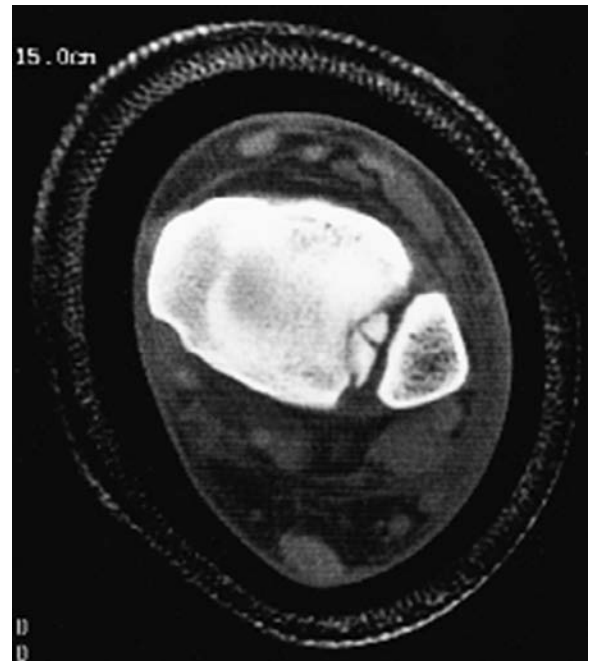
Incisural fracture: CT scan at the level of the tibiotalar joint demonstrates that the fracture fragment does not include the attachment of the anterior-inferior tibiofibular ligament.
